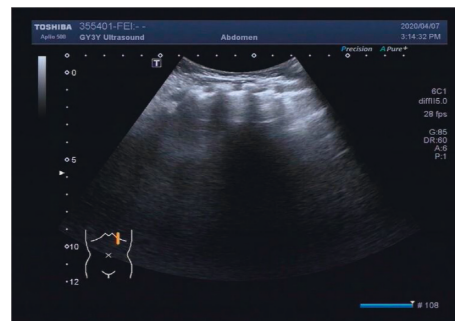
Left congenital cystadenoma. CT showed increased transmittance of the posterior segment of the upper lobe and the dorsal segment of the lower lobe of the left lung, with a range of about $38.5 \times 26.6 \times 42.9\text{ mm}$, with multiple round areas of different sizes, with a maximum diameter of about 7.7 mm , some of the walls slightly thicker, enhancement of the cyst wall, thickened pulmonary artery blood supply, and cystic adenomatoid malformation of the lung (type II). Ultrasound revealed irregular hypoechoic pulmonary consolidation areas, pleural lines were not smooth and unclear, A-lines decreased or disappeared, and dense B-lines or B-lines fused.
